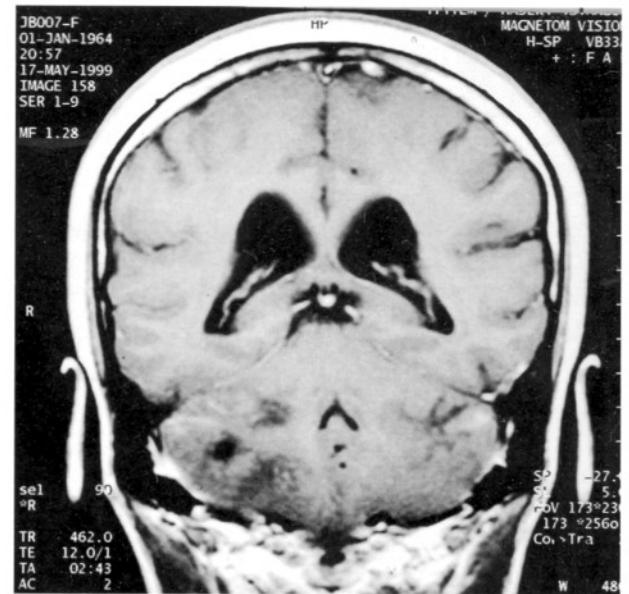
Post-contrast T1-weighted coronal MR scan shows, 2 different lesions on both cerebellar hemispheres. They have heterogenous contrast enhancement and cystic components. Vermis is intact.
